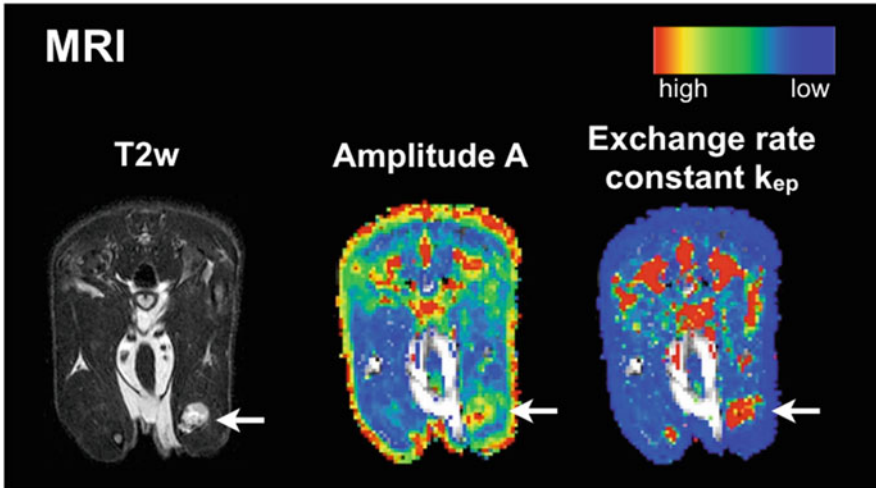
Axial MR sections. *Left panel*, T2w MRI; *middle panel*, amplitude A (DCE-MRI, associated with blood volume); *right panel*, exchange rate constant k_{ep} (DCE-MRI, associated with perfusion and vessel permeability) according to the pharmacokinetic model of Brix. *Arrows* point at bone metastases. The color map for DCE-MRI data ranges from *red* (high values) to *blue* (low values). *Arrows* point at bone metastasis. Figure reprinted with permission from [14]
